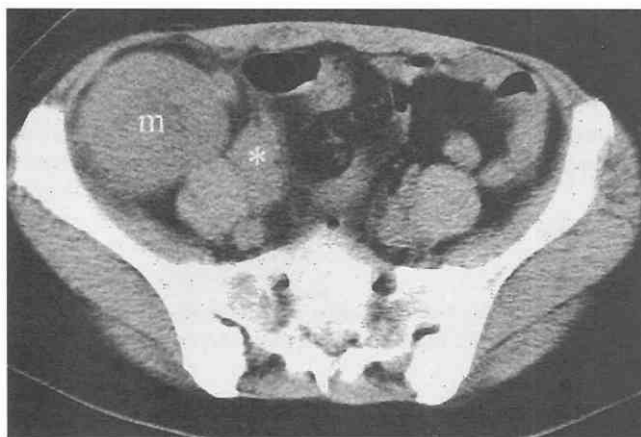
Post-transplantation lymphoproliferative disorder. Unenhanced CT scan shows an ill-defined mass in the transplanted kidney (m), which appeared as a heterogeneous mass lesion on ultrasound examination. Another mass (asterisk) is noted along the ureteral course.
